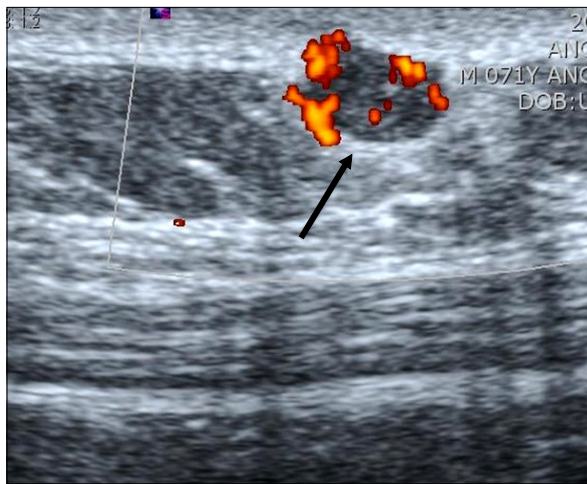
Ultrasonography imaging. Revealed a $4.7 \times 3.6 \text{ mm}^2$ sized nodule with increasing focal blood flow, which had a well-circumferenced hypoechoic character suspicious of infected sebaceous cyst or epidermal cyst.
